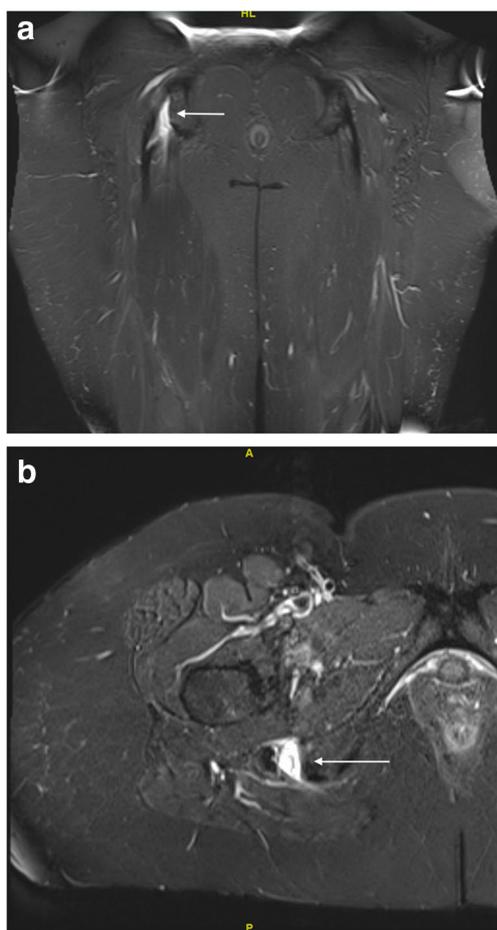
“Sickle sign” demonstrating partial-thickness hamstring tear of the proximal origin. a Coronal T2-weighted MRI image. b Axial T2-weighted MRI image
